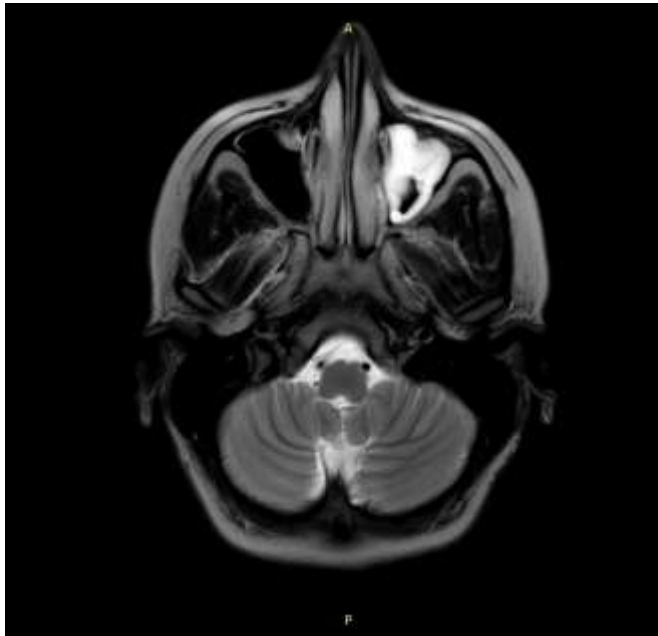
Axial MRI brain T2W-MV image for patient number 10 shows left maxillary sinusitis that appear hyperintense and partial opacification of left antrum.
